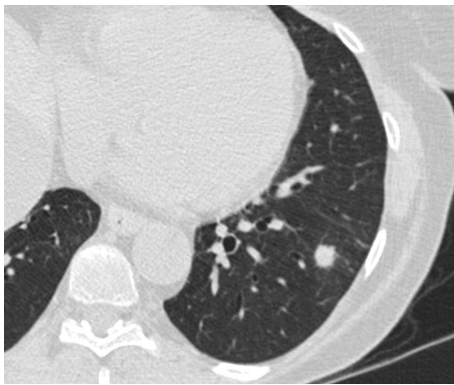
Typical appearance of an indeterminate solid pulmonary nodule at high-resolution computed tomography (Philips 16-slice computed tomography, slice thickness 1.25 mm) in a 59-year-old female patient. The lesion was located in the left lower lobe, had a maximum diameter of 10 mm and proved to be a non-tubercular granuloma at surgery.
